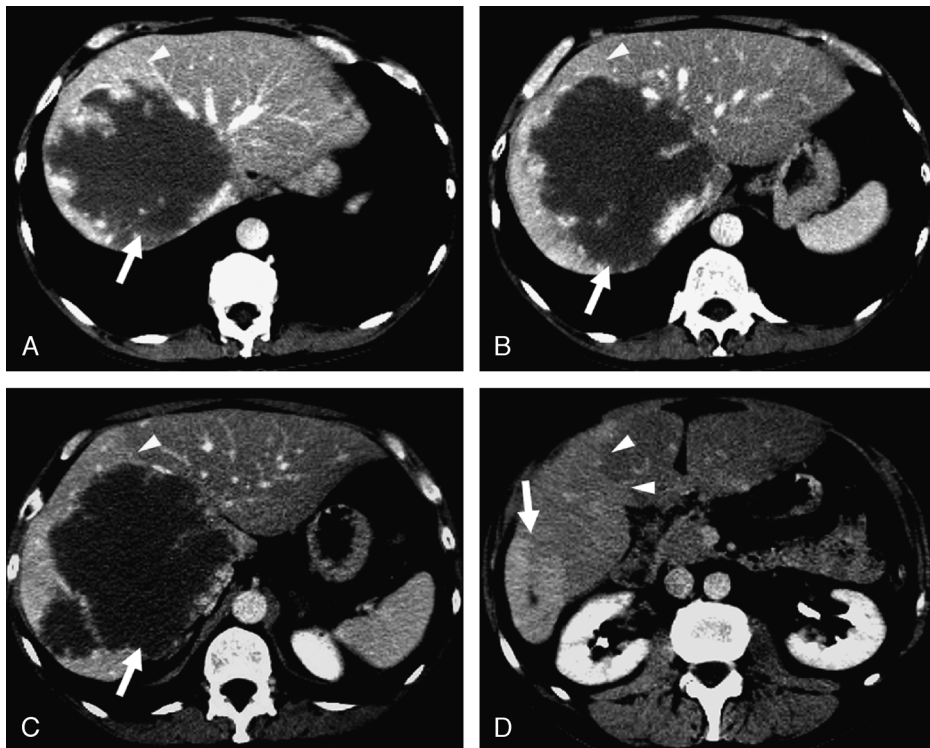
A 51-year-old man (number 7 of our series) with siphoning transient hepatic attenuation differences in the right liver lobe caused by large hemangioma. A–C, Artery phase CT scans show large hypoattenuating hemangioma (arrows) in segments VI, VII, and VIII sited within arterial phenomenon involving the entire right lobe (arrowheads). D, Portal vein phase CT scan shows, in a caudal scan, hyperattenuating hemangioma (arrow). Associated arterial phenomenon is still visible (arrowhead), maybe owing to long-duration capability of hemangioma to draw blood flow (slow fill-in phenomenon) or to compression on medial hepatic vein.
